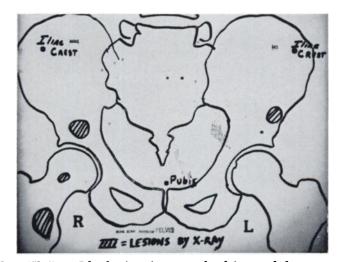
Case IX. Bone Islands. Anterior scan of pelvis revealed no areas of increased ⁸⁵Sr concentration indicating no active bone lesions. Roentgenogram had suggested the possibility of osteoblastic metastases to the areas marked on the scan.
